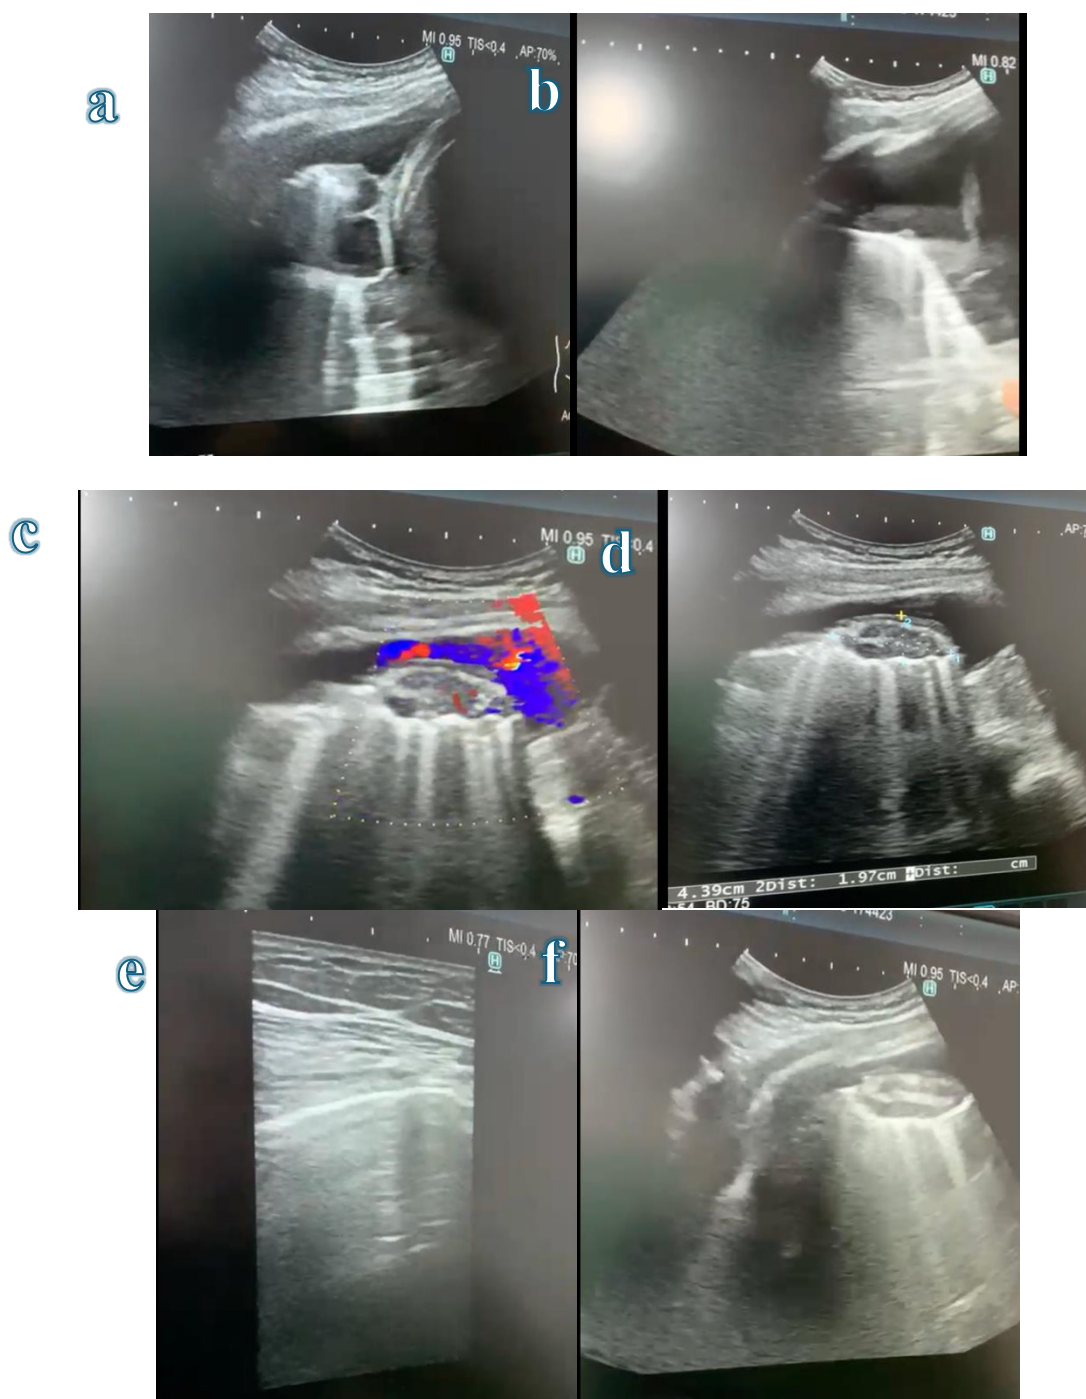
Lung ultrasound showed different patterns of lung affection: (a & b): Moderate pleural effusion with septations and collapse of lower lobe (Severity Score = 0), (c & d): consolidation patch with air-bronchogram measuring 4.39x1.97 cm (Severity Score = 3), (e): Excessive B lines more than 3 (Severity Score = 2), (f): A-lines (Severity Score = 0). The total LUS score was 10/ 36.
